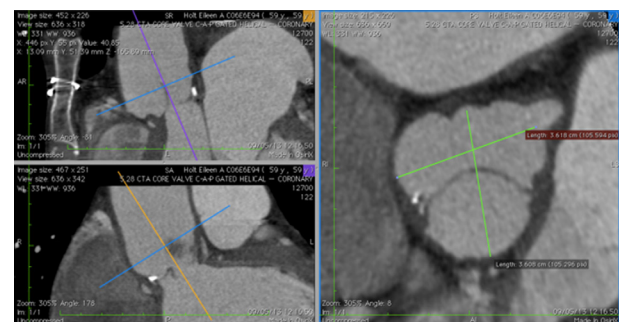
CT image of pre-TAVR stentless aortic valve in cross section.
